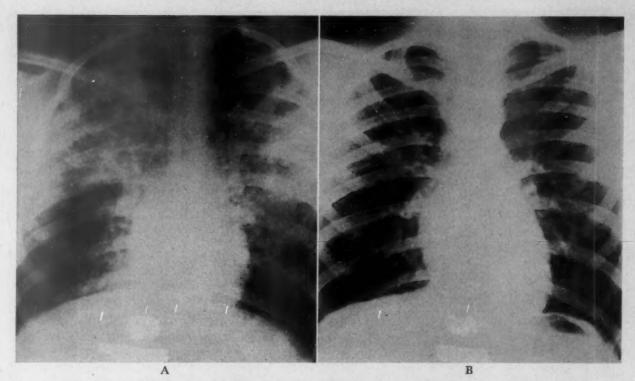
Case 9. A, x-ray film of the chest taken at sea level soon after arrival (August 14, 1955). B, four days after (August 18). The only treatment was bed rest.
